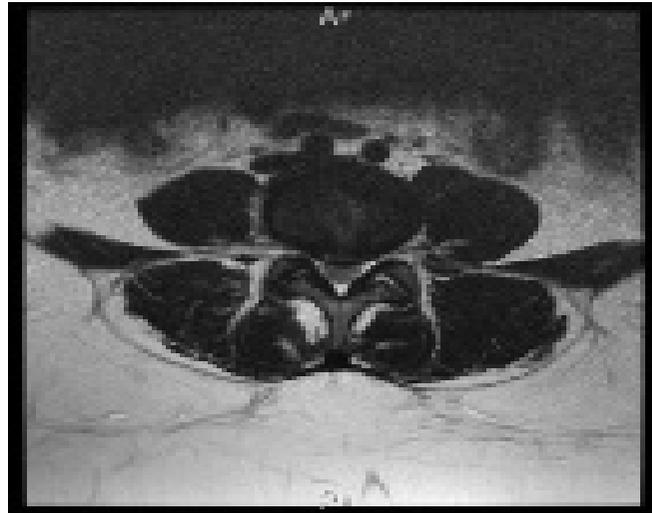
MRI Lumbar Spine, Showing L 4/5 Disc Bulge with Bilateral L5 Root Compression (Sagittal Weighted T2 images)
